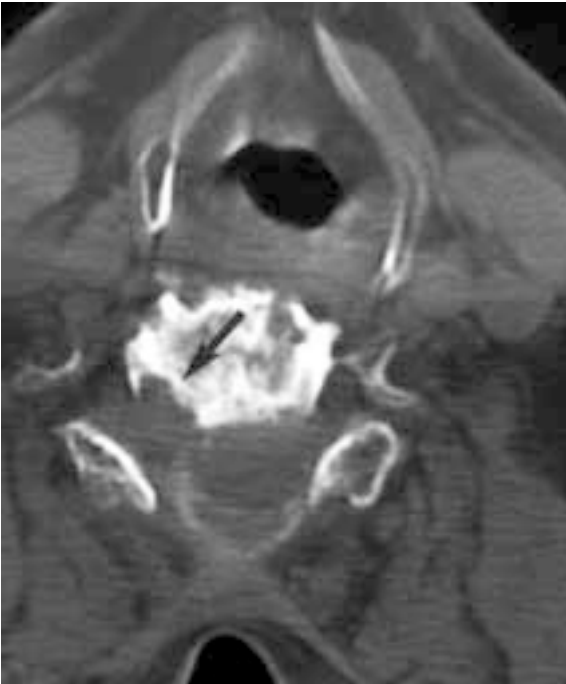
Axial CT scan taken through the C5 level following a myelogram in a 73-year-old Caucasian man. Note the posterior displacement and compression of the cervical cord by a recurrent chordoma arising from the C5 vertebral body. The recurrent tumour is of soft tissue density and has extended into the right paravertebral space through an eroded right exit foramen (arrow). A midline scar indicates previous surgery with incomplete tumour resection.
